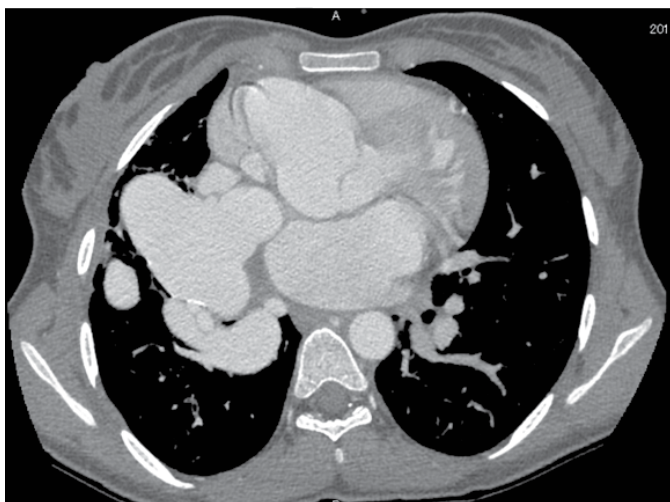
Contrast enhanced cardiac computed tomography In multidetector computed tomography scanner- grossly dilated right coronary artery having fistulous communication with dilated venous sac draining into left atrium. Largest sac measures 7x5 cm. wall calcification can be appreciated suggesting long standing process.
